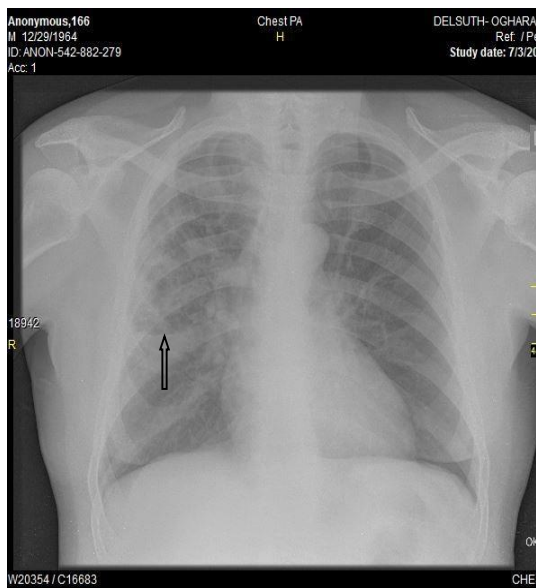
Posteroanterior chest radiograph of a 56-year-old male HIV sero-positive PTB patient showing a cavity in the right mid lung zone (arrow). There are also widespread inhomogeneous infiltrates in the right upper and mid lung zones.
